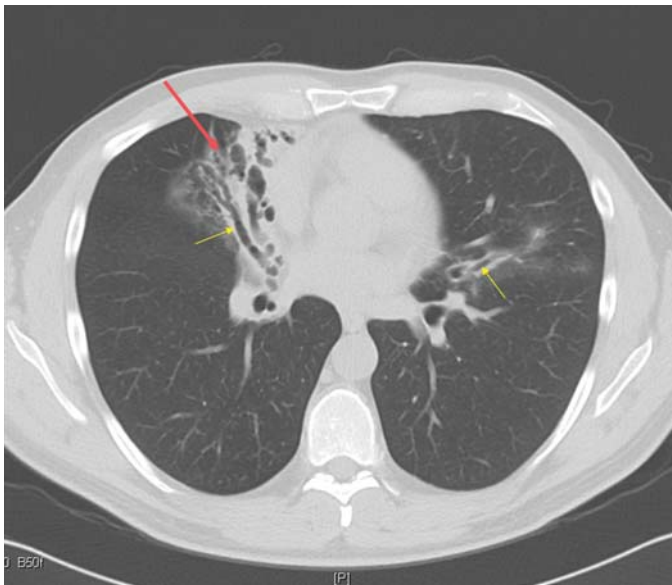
FIGURE e24-33 CT scan of focal right middle lobe and lingular bronchiectasis (yellow arrows). Note that there is near total collapse of the right middle lobe (red arrow).
